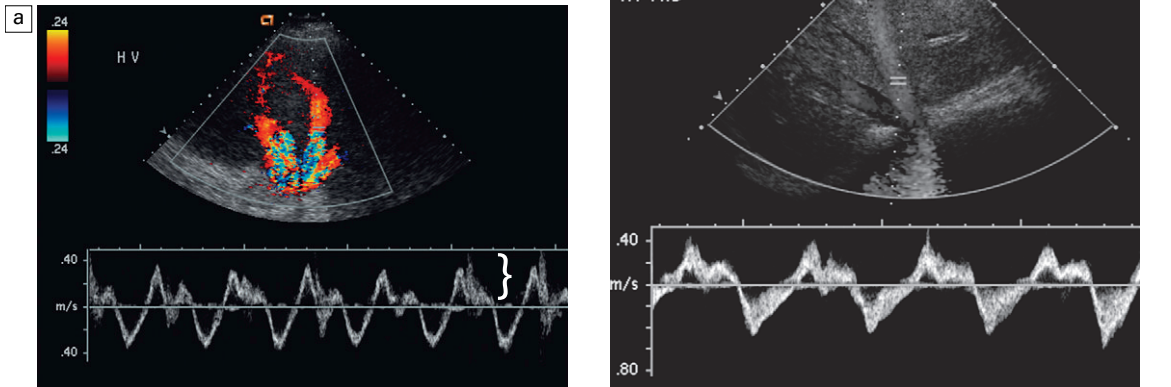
(a) Transverse spectral and colour Doppler view of the hepatic veins. The hepatic veins are markedly engorged as would be expected with chronic cardiac congestion. Spectral Doppler waveform shows appropriate periodicity within these vessels. The overall amount of retrograde flow, however, is disproportionately large. When summing the area of flow above and below the baseline it becomes apparent that there is relatively little total antegrade flow as would be expected with cardiac congestion. (b) Spectral Doppler tracing in another patient with cardiac congestion. Although periodicity is identified in the tracing it is more disordered than the standard triphasic waveform. Flow away from the heart (above the baseline) is only slightly less than flow towards the heart (below the baseline). This decreased total antegrade flow is a manifestation of cardiac ingestion.
